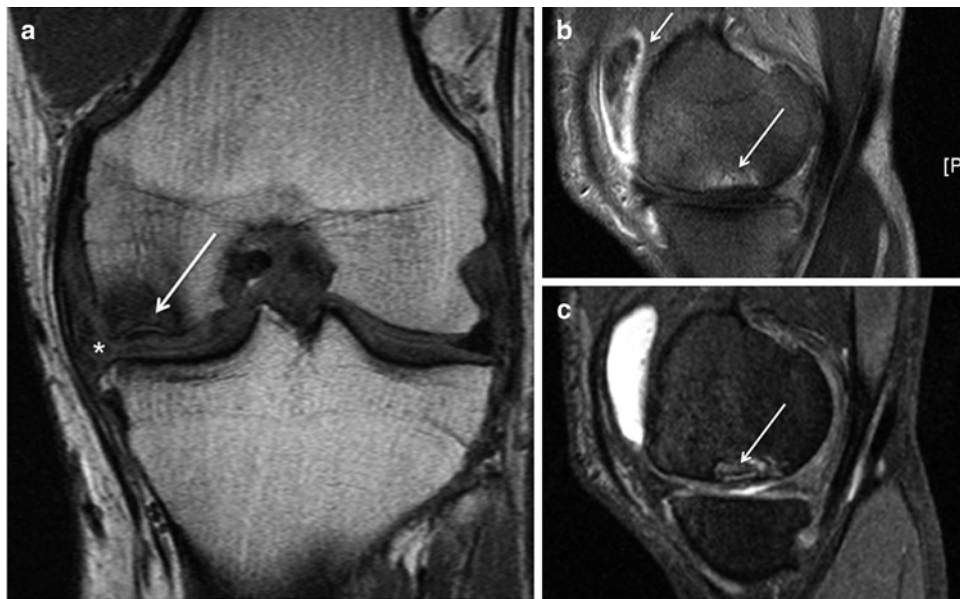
Coronal T1-weighted FSE sequence (a), sagittal contrast-enhanced fat-saturated (fs) T1-weighted FSE sequence (b) and dual-echo steady-state (DESS) sequence (c) of the knee in a patient with an insufficiency fracture (previously SONK) at the medial femoral condyle
